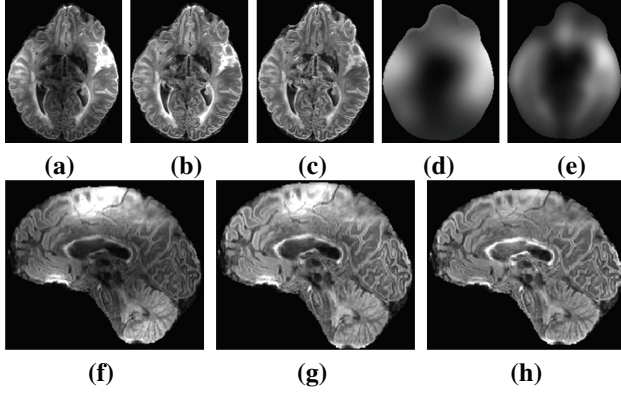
(a) Original 7T FLAIR image, (b) N3 corrected FLAIR, (c) CSI-NC corrected image, (d) N3 field, (e) smoothed field from CSI-NC, smoothed by Gaussian filter of size 10mm, (f) a sagittal view of the original FLAIR, (g) sagittal view of N3 corrected image, (h) sagittal view of CSI-NC corrected image. As N3 assumes an underlying smoothness model on the inhomogeneity, small localized inhomogeneity that are present in small tissue structures are not corrected.
